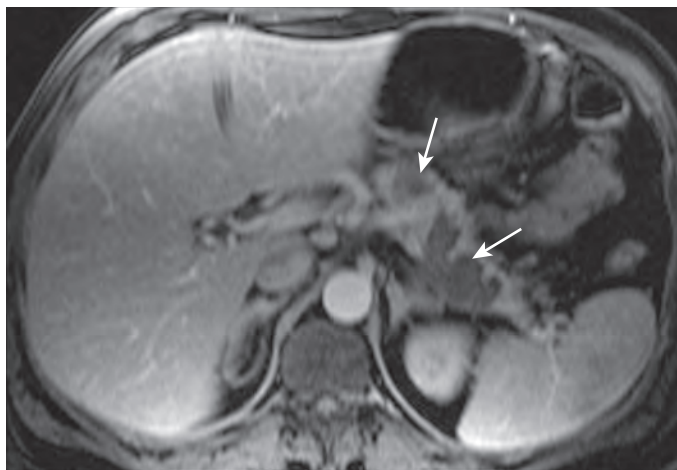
Pancreatitis with necrosis involving more than 50% of the gland. Axial gadolinium-enhanced T1-weighted fat-suppressed spoiled gradient-echo MR image shows nonenhancing necrotic areas (arrows) in the body and tail of the pancreas. (From Ly JN, Miller FH: MR imaging of the pancreas: A practical approach. *Radiol Clin North Am* 40:1289–1306, 2002.)
